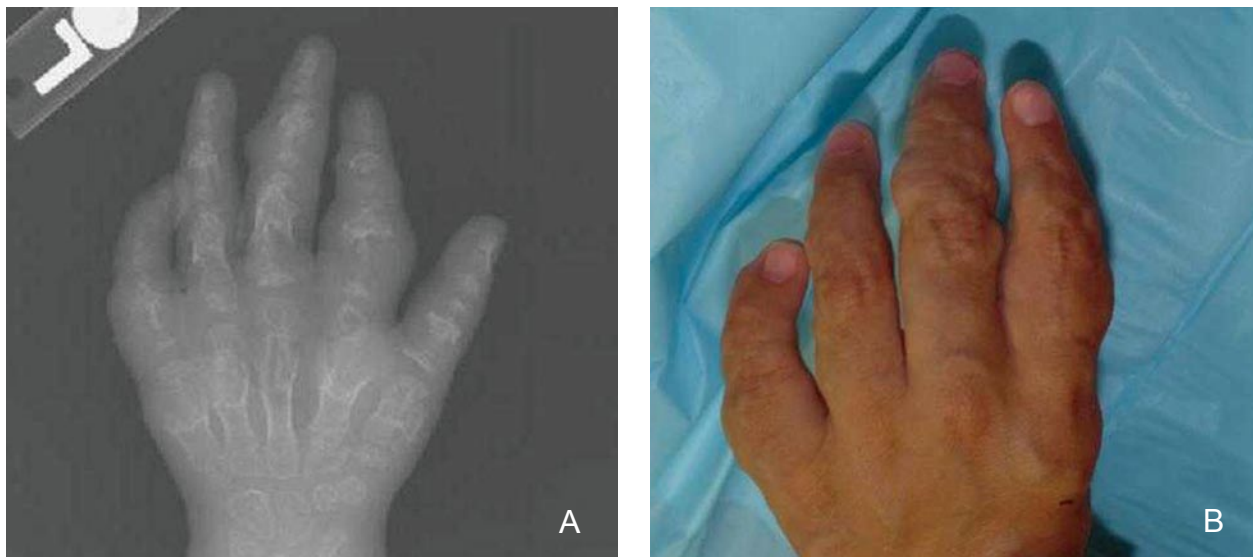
Radiograph of left hand demonstrating multiple enchondromas (A). Left hand with multiple compressible purple nodules demonstrating venous malformations (B).
